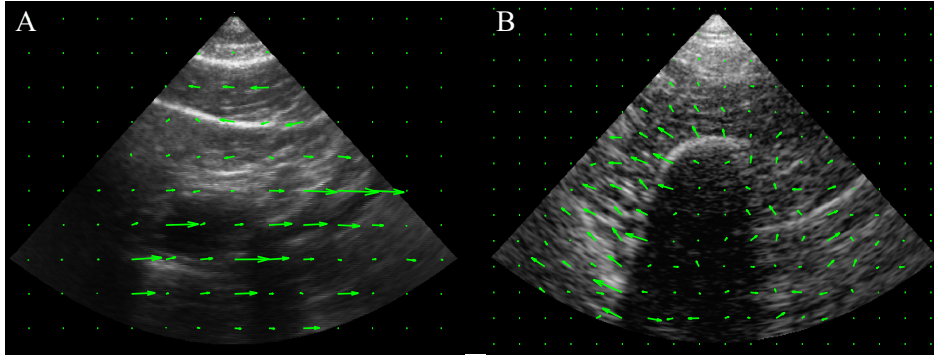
Velocity fields extracted from ultrasound images of (a) abdominal organs, and (b) the upper leg. Images were acquired at resonance frequencies of 4 Hz for the stomach and 8 Hz for the femur.
